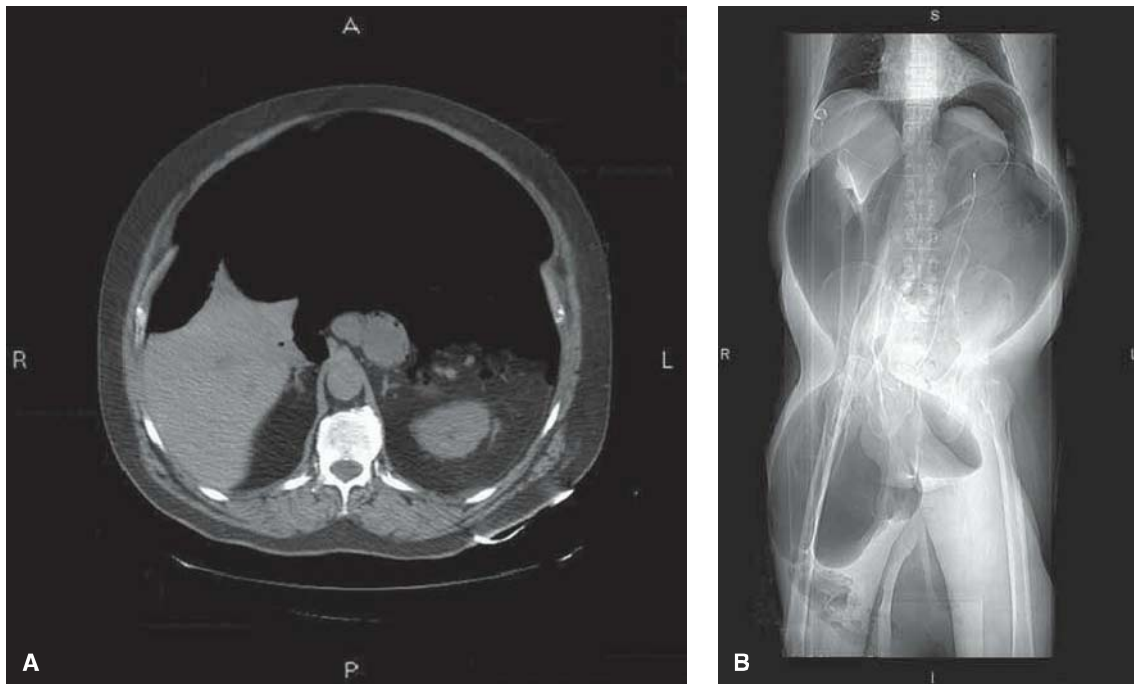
(A and B) CT scans of patient receiving progressive preoperative pneumoperitoneum indicating adequacy of the insufflation.
